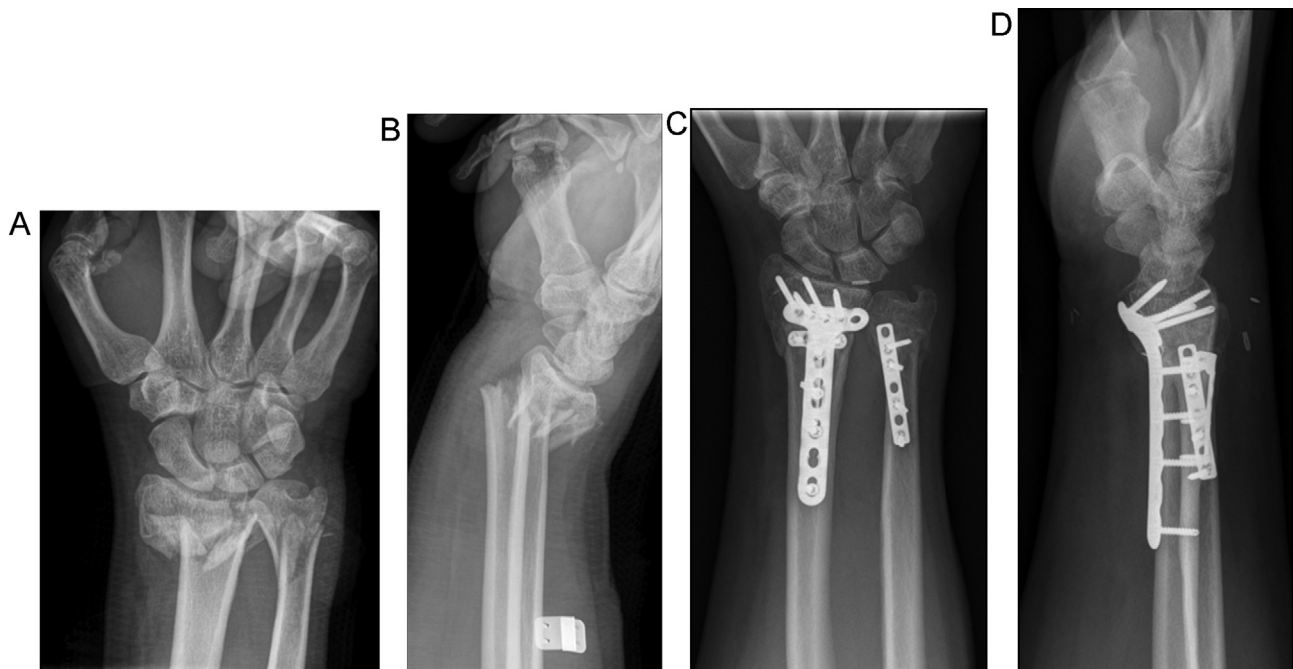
Anteroposterior (A) and lateral (B) view radiographs show a type C3, Grade 1 open fracture of the distal radius and an ulnar neck fracture in a 67-year-old man who fell from a standing height. Anteroposterior (C) and lateral (D) view radiographs of the wrist, obtained 7 months after surgery, show anatomic reduction and uneventful healing.
